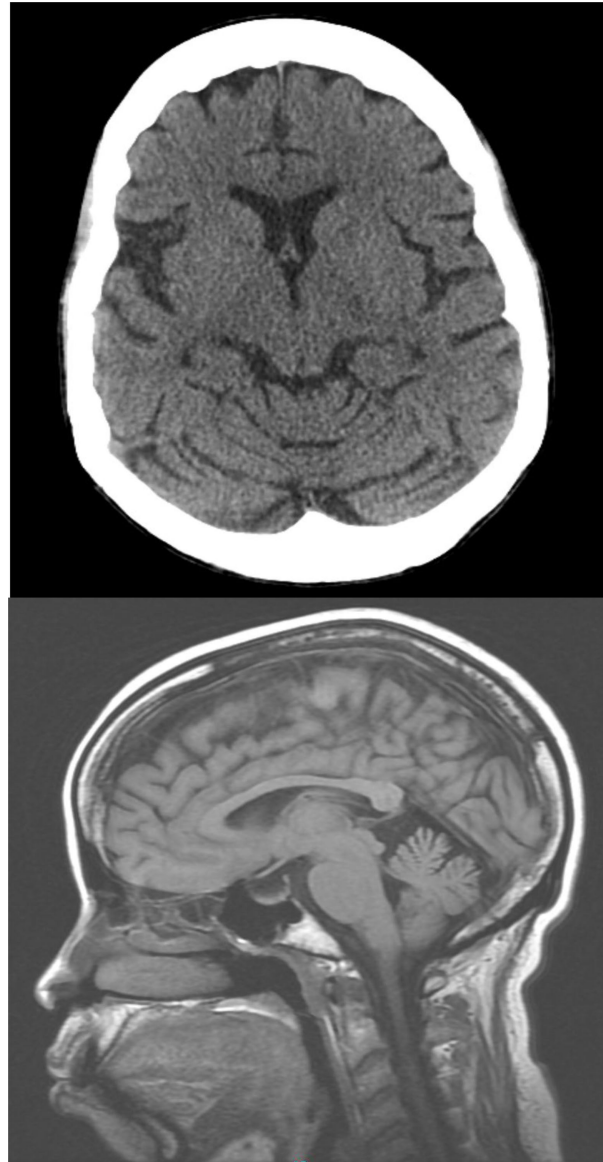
Axial CT and Sagittal MRI of the brain show significant age-inappropriate diffuse cerebral atrophy.
